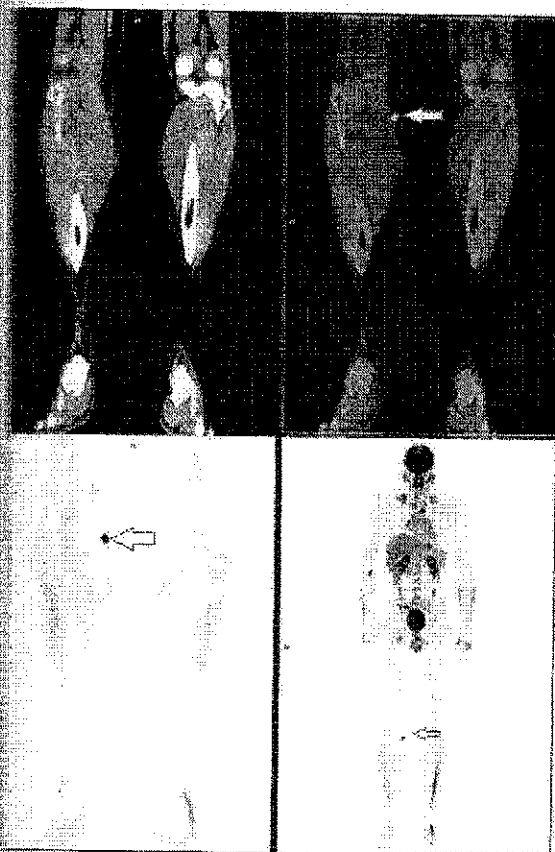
GDV, 38y. SSM on the right leg, pT3aNsl(0), IIA. PET/CT in the follow-up: 06'21 – single hypermetabolic subcutaneous lesion of <1cm on right shank, cranial from primary (arrow). Restaged in stage IIIB, target therapy started.
